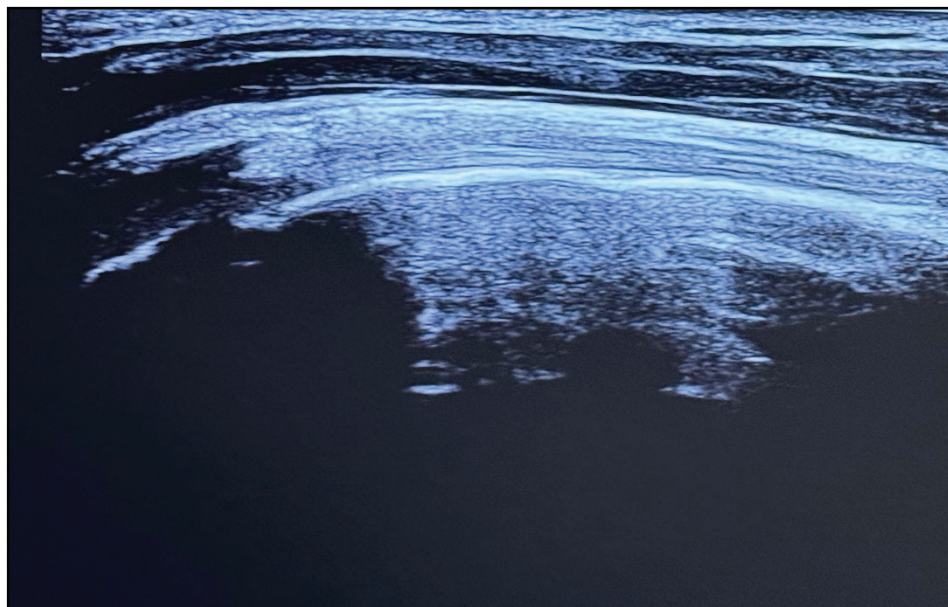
Ultrasound-guided image showing the bicipital tendon in the long-axis view
